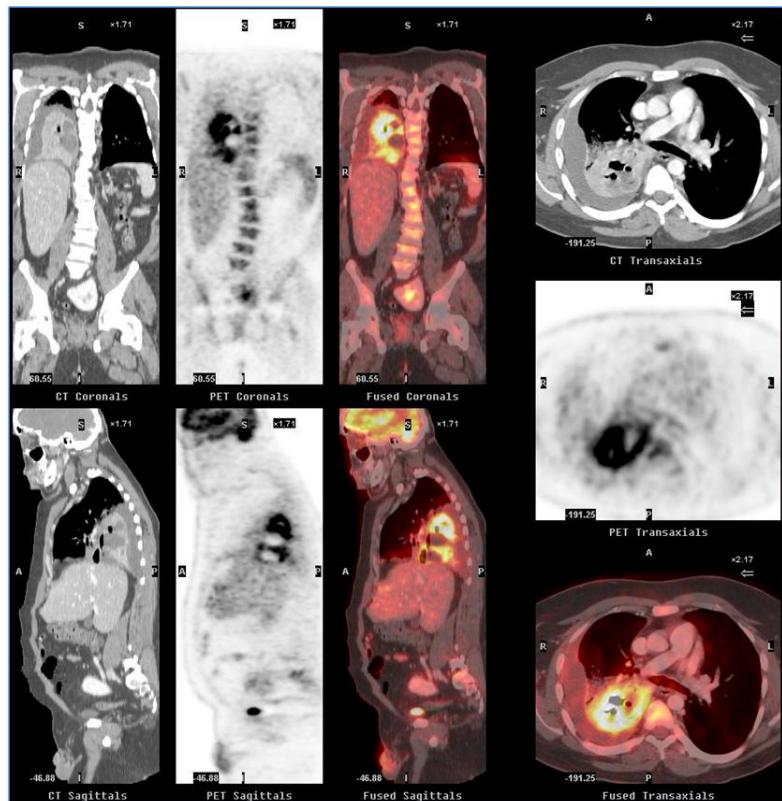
Coronal and sagittal sections of the entire body with CT, PET and combined images. Axial sections. False positive: Necrotizing pneumonia of middle lobe and lower right lobe with effusion.
